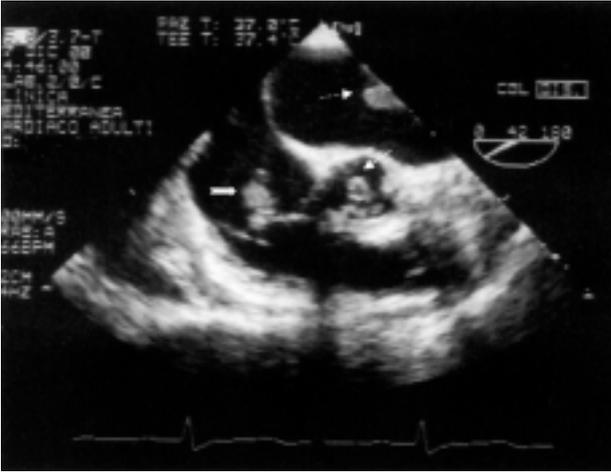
Transesophageal echocardiographic short-axis view of the aortic valve showing a vegetation on the ventricular face of the right coronary cusp (thin arrow), another vegetation on the atrial face of the anterolateral leaflet of the tricuspid valve (large arrow) and the mitral vegetation swinging in the left atrium (dashed arrow).
